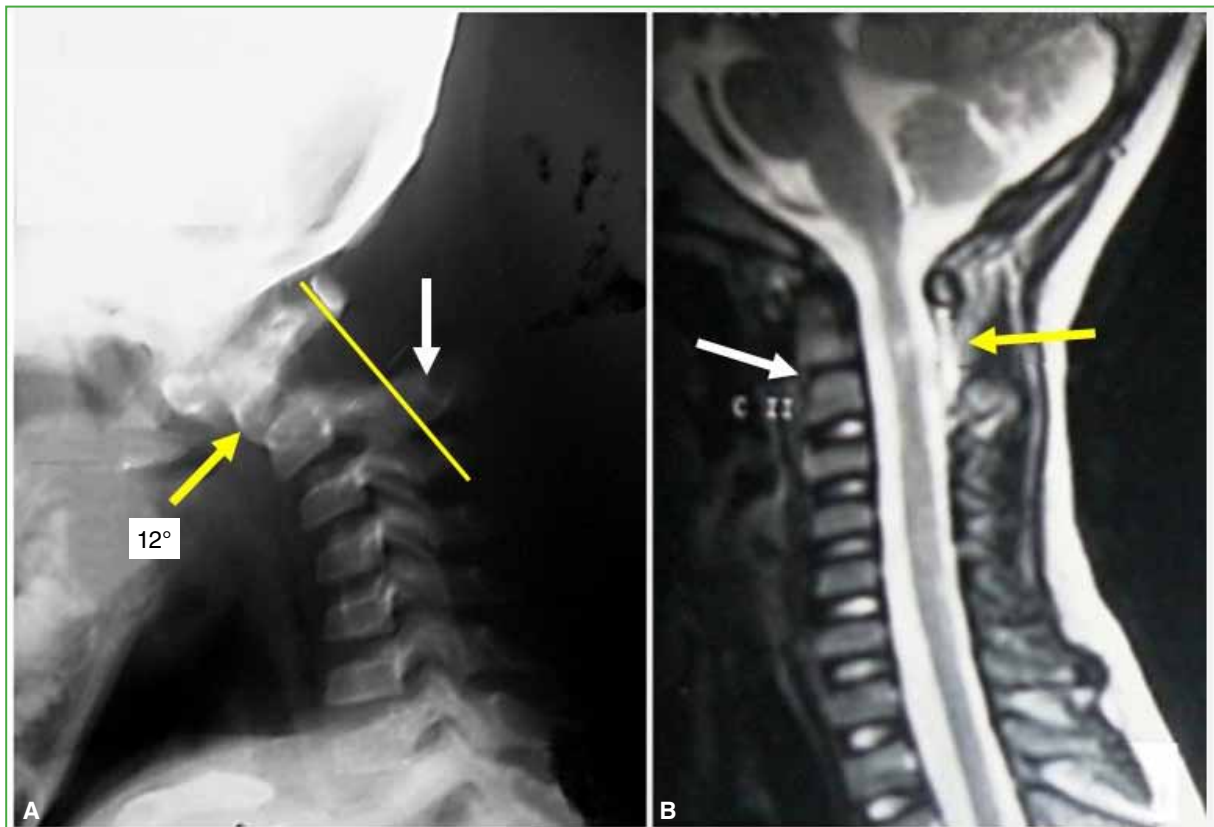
Four-year-old girl who fell from a height, presenting with Frankel D neurological status. Cervical spine images on admission. A. Radiograph: dentocentral epiphysiolysis of the axis in flexion, with anterior displacement of the odontoid process (yellow arrow). Kyphosis of 12 degrees, with the spinolaminar line of C2 clearly posterior to the SL (white arrow). B. MRI: separation of the dentocentral synchondrosis (white arrow), with posterior and intracanal fluid signal (yellow arrow) and edema of the bone marrow parenchyma.
